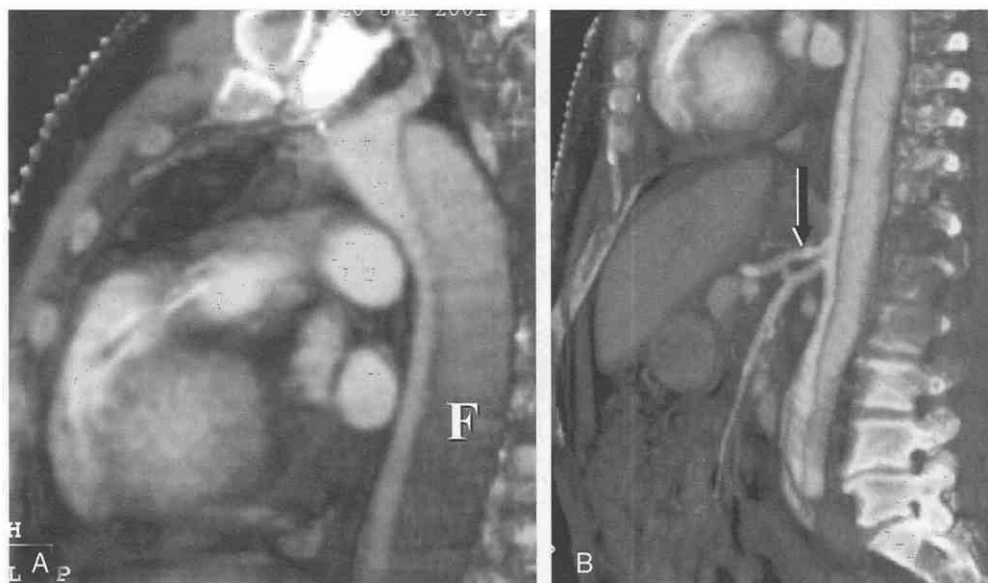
A, Sagittal oblique volume-rendered, multislice CT scan demonstrates a compressed true lumen with slow flow through the posterior false lumen (F). B, Sagittal oblique multislice CT scan shows the smaller true lumen giving rise to the celiac axis (arrow) and superior mesenteric artery.
